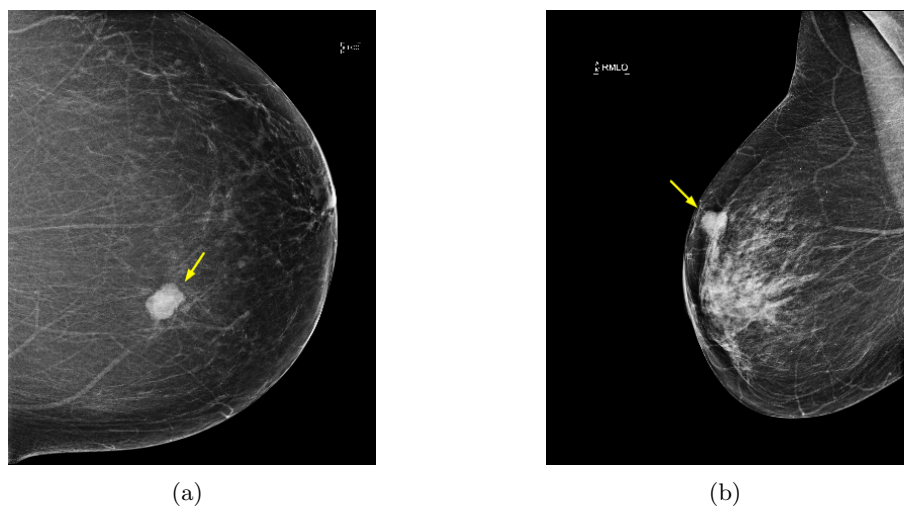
Sample X-ray mammography images showing signs of breast cancer.
